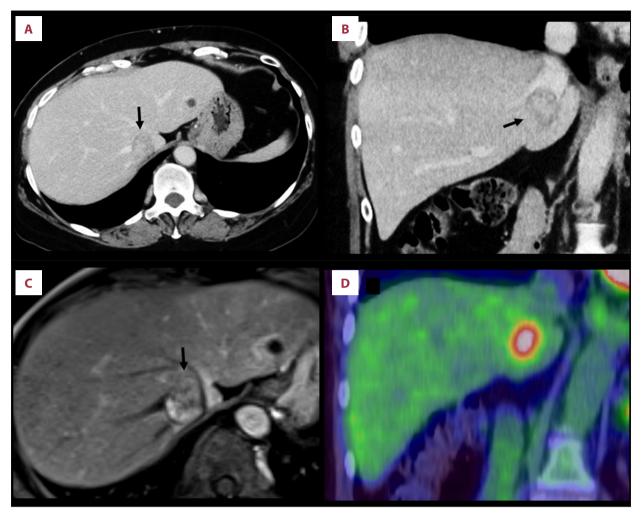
Image findings of tumor recurrence at 31 months after the first operation. (A) Axial and (B) coronal views of enhanced computed tomography images in the venous phase show a solitary, low-density, mass lesion 2.5 cm in size that was observed in the liver parenchyma adjacent to the right hepatic vein, middle hepatic vein, and the stump of the vena cava (black arrow). (C) Gadoxetate sodium-enhanced magnetic resonance image shows a partially hypervascular liver mass in the arterial phase (black arrow). (D) Positron emission tomography shows an accumulation of <sup>18</sup>F-fluorodeoxyglucose in the tumor lesion.
